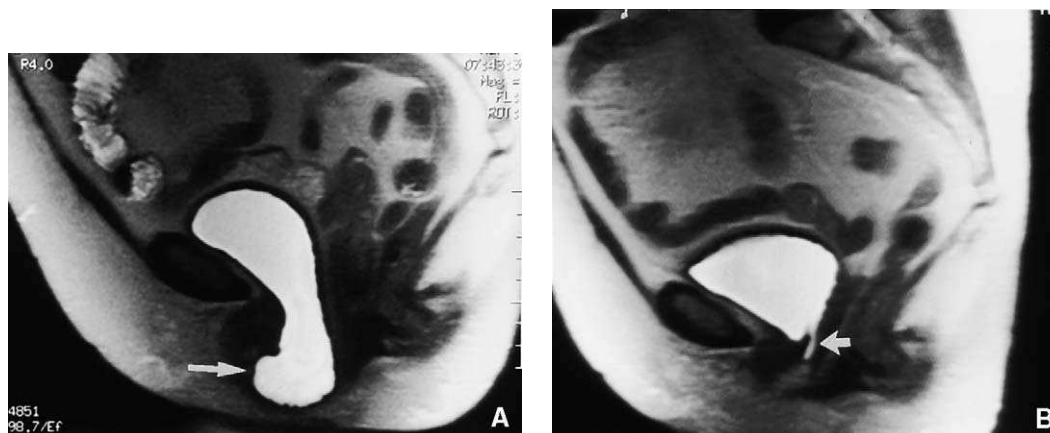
Cystocele and vaginal vault prolapse in a 74-year-old woman. (A) Sagittal T2-weighted MR image (2200/96) obtained at maximal strain shows a large cystocele (arrow). (B) After surgical repair, midline image obtained with the same MR parameters shows a small residual posterior fascial defect (arrow). (From Fielding JR. Practical MR imaging of female pelvic floor weakness. Radiographics 2002;2:295–304; with permission.)
